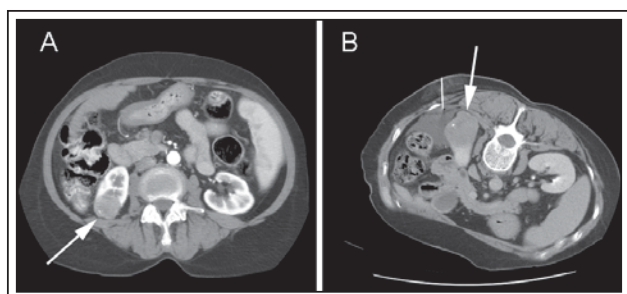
a) Contrast CT of abdomen and pelvis showing 2.8 cm x 3.0 cm right lower pole renal mass; b) Contrast CT of abdomen and pelvis performed 2 months later, demonstrating interval growth of the right renal mass to 3.8 cm x 4.5 cm.
